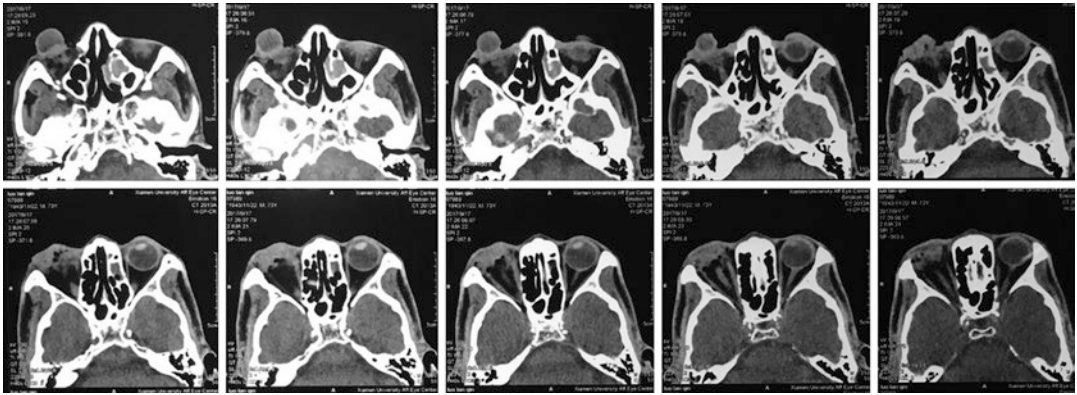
CT scan showed the laceration of optic nerve and hemorrhage behind the eyeball
